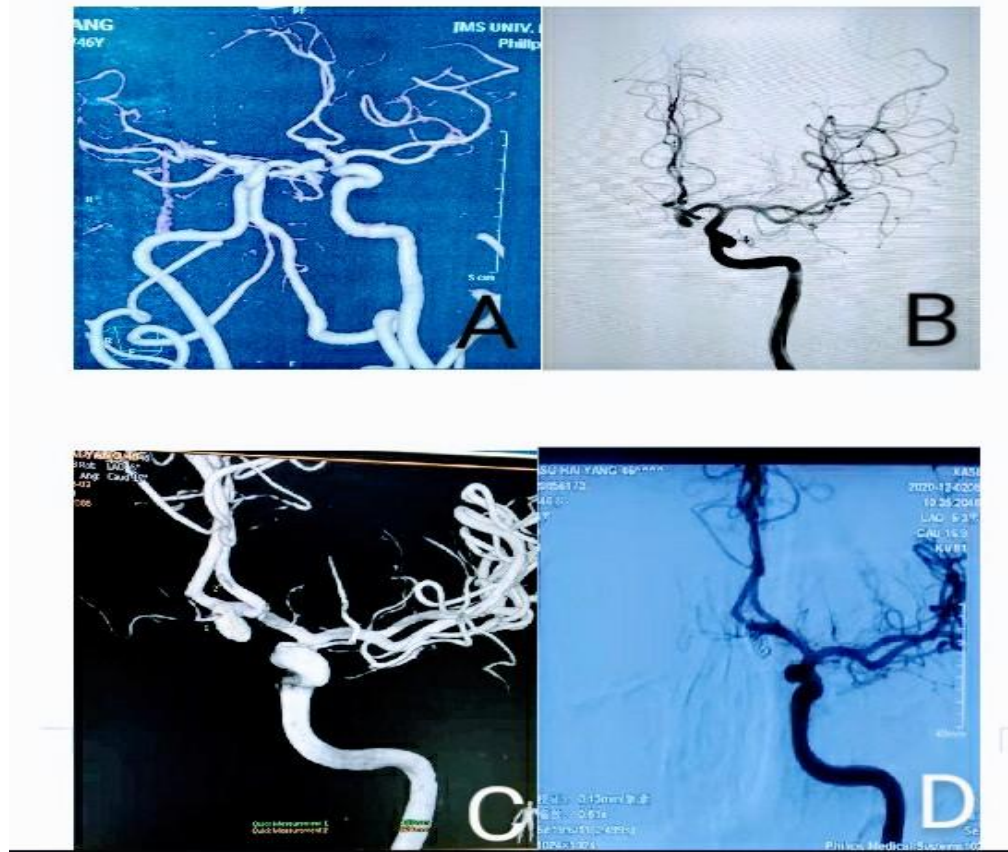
computed Tomography Angiography (A) showed an anterior communicating artery aneurysm and absence of right A1 segment of anterior cerebral artery. Digital subtracted Angiography (B, C) showed the Acoma aneurysm measured 4.5 mmx 8 mm. (D) post-coiling angiogram showed Modified Raymond-Roy Class II occlusion of the aneurysm
